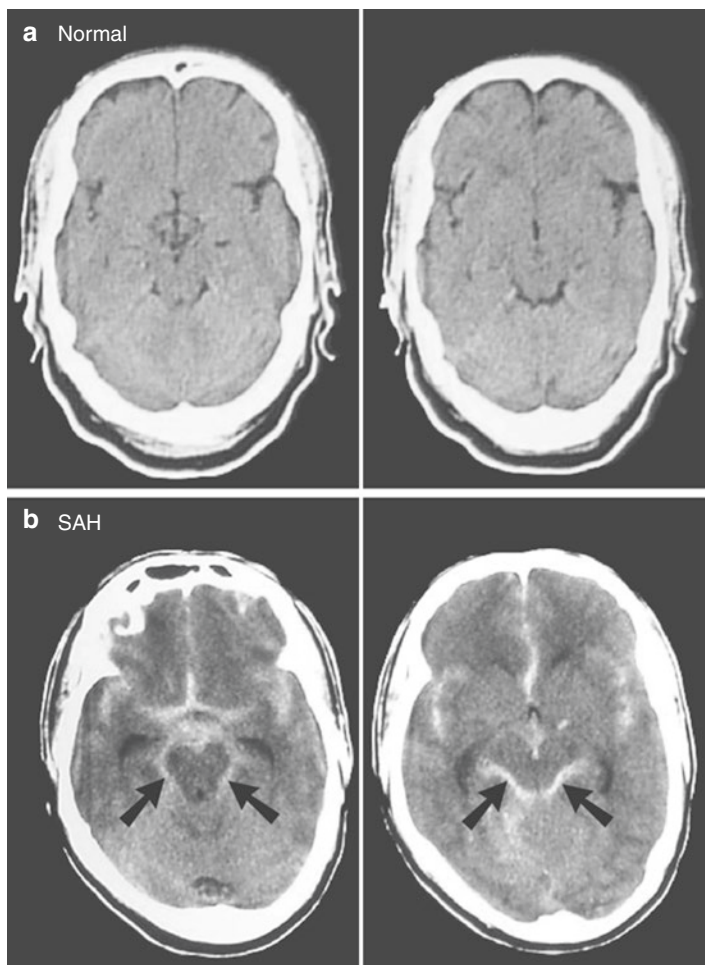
Normal brain CT scan with normal ambient cisterns with hypodense CSF (a) and what they look like in the presence of subarachnoid hemorrhage (black arrows) in the image pair below (b). Note that there is widespread blood in the other CSF spaces as well (interhemispheric, sylvian fissure and the suprasellar cisterns)
